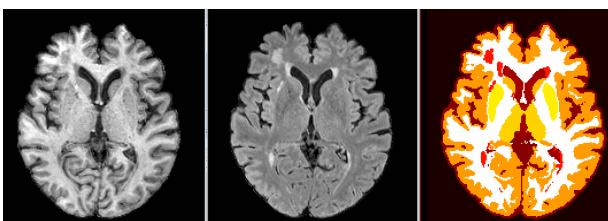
MPAGE, FLAIR, and segmentation
